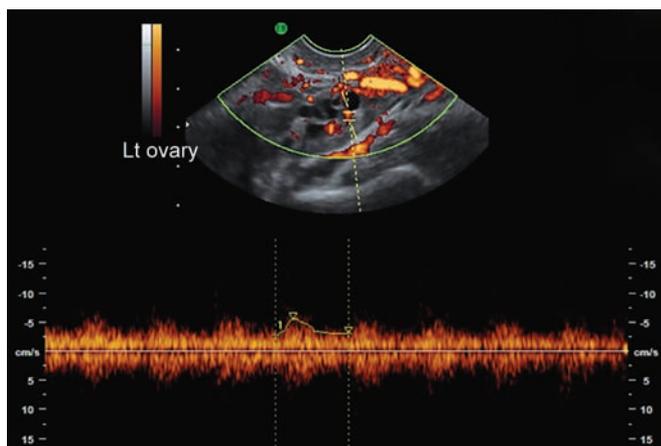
Power Doppler with pulsed Doppler showing quantitative assessment of the ovarian stromal flow
